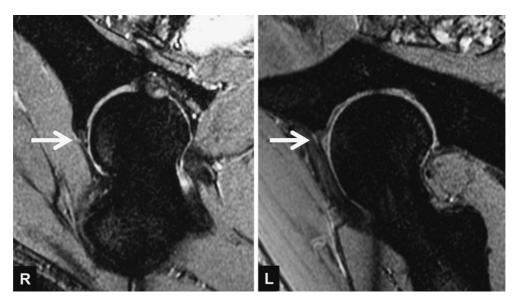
Magnetic resonance imaging of both hips White arrows indicate the labral injuries in both hips.
